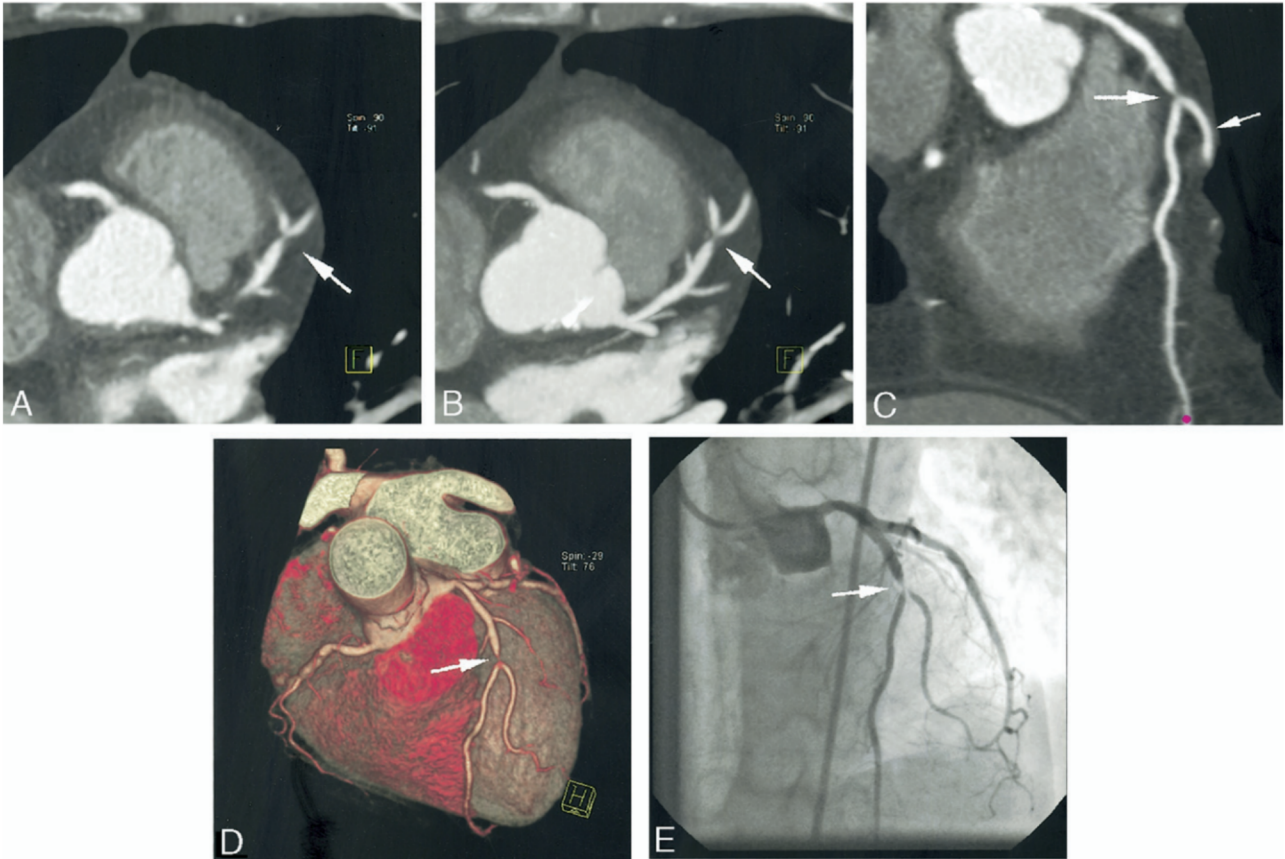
Stenotic lesion in a human LAD coronary artery visualized by computer tomography coronary angiography. A - Transaxial CT image (0.75 mm slice thickness) showing the stenosis (Arrow) in the LAD coronary artery; B - Improved visualization of the stenotic segment (Arrow) in a maximum intensity projection (5mm slice thickness); C - Curved multiplanar reconstruction visualizes that the stenosis affects the main LAD (Larger arrow) and a side branch (Smaller arrow); D - 3D reconstruction shows the stenosis of the LAD located proximal to the side branch bifurcation (Arrow); E - Corresponding invasive angiography image of the stenosis (Arrow); [43].
